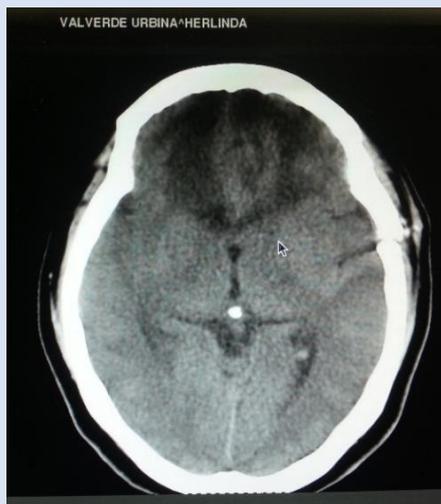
Control CT 10 days after HSA
